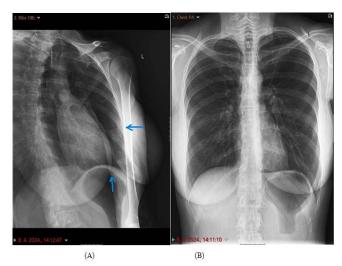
(A) Radiological image of the thorax. Chest oblique and posteroanterior radiograph projection view (B). The blue arrow points an visible fractures of the left sixth and ninth ribs.
